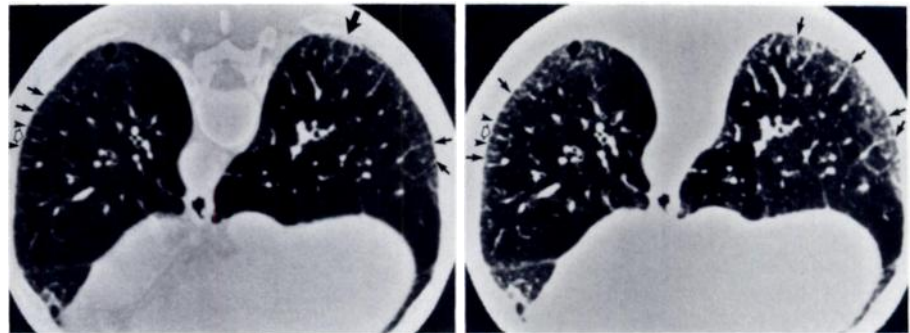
High-resolution CT scans with subject prone, displayed at two CT window parameters used for interpretation of lung parenchyma.
